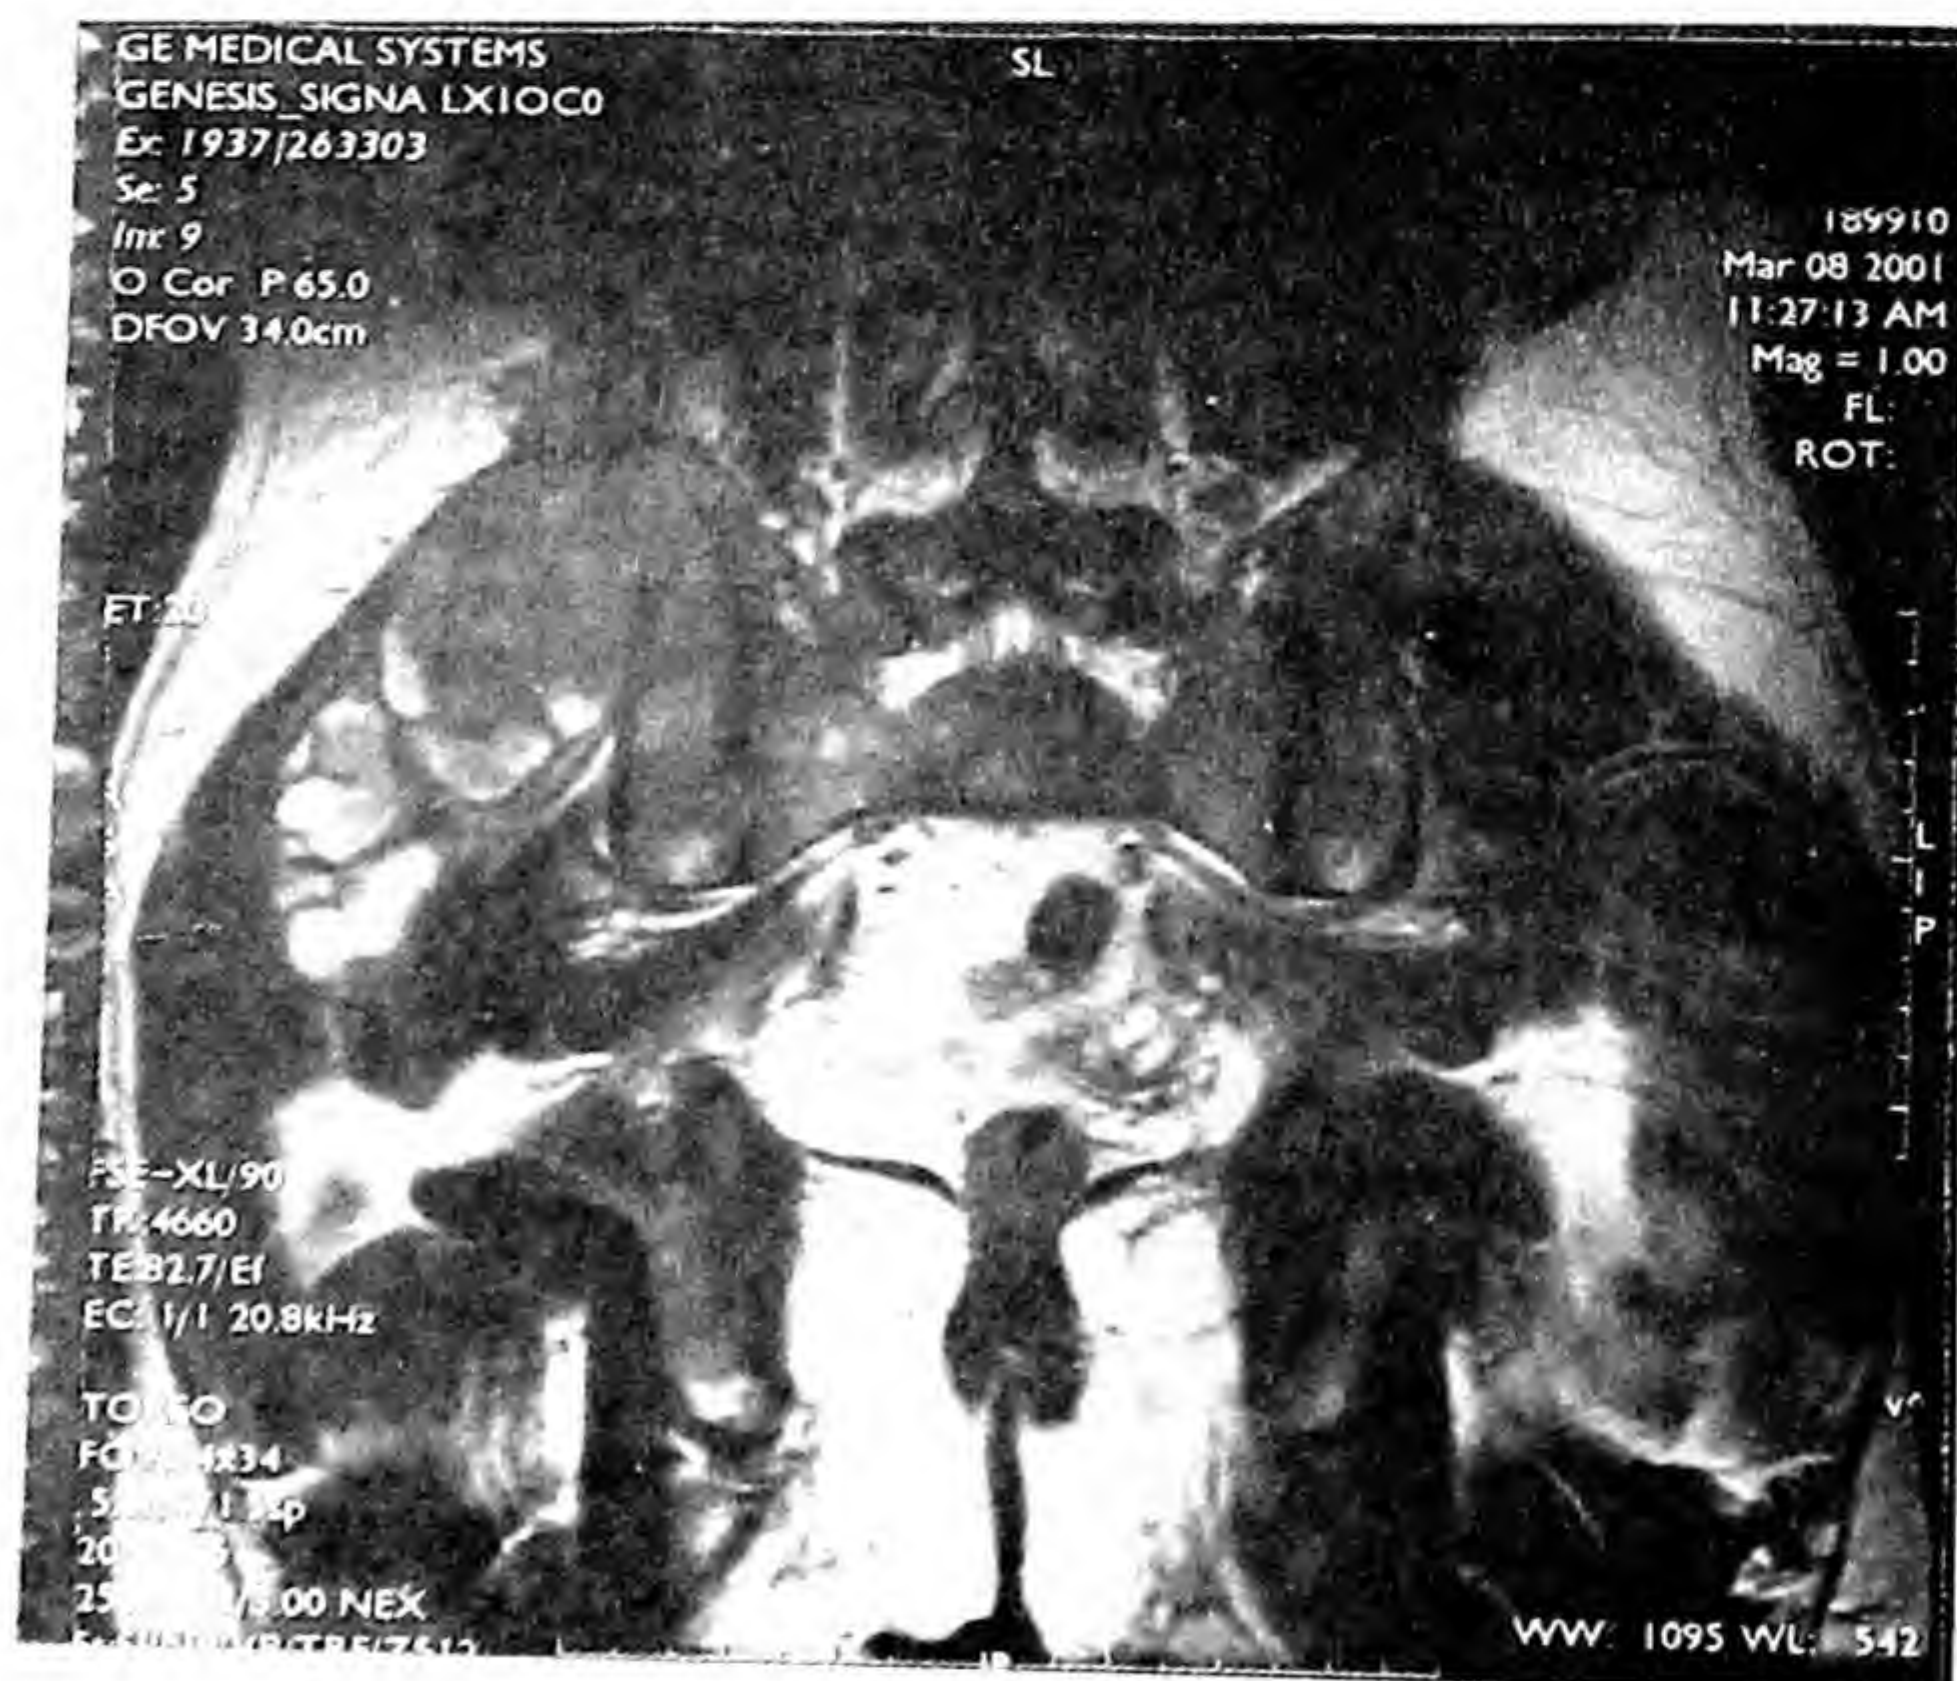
MRI scan of pelvis showing involvement of gluteal muscles
